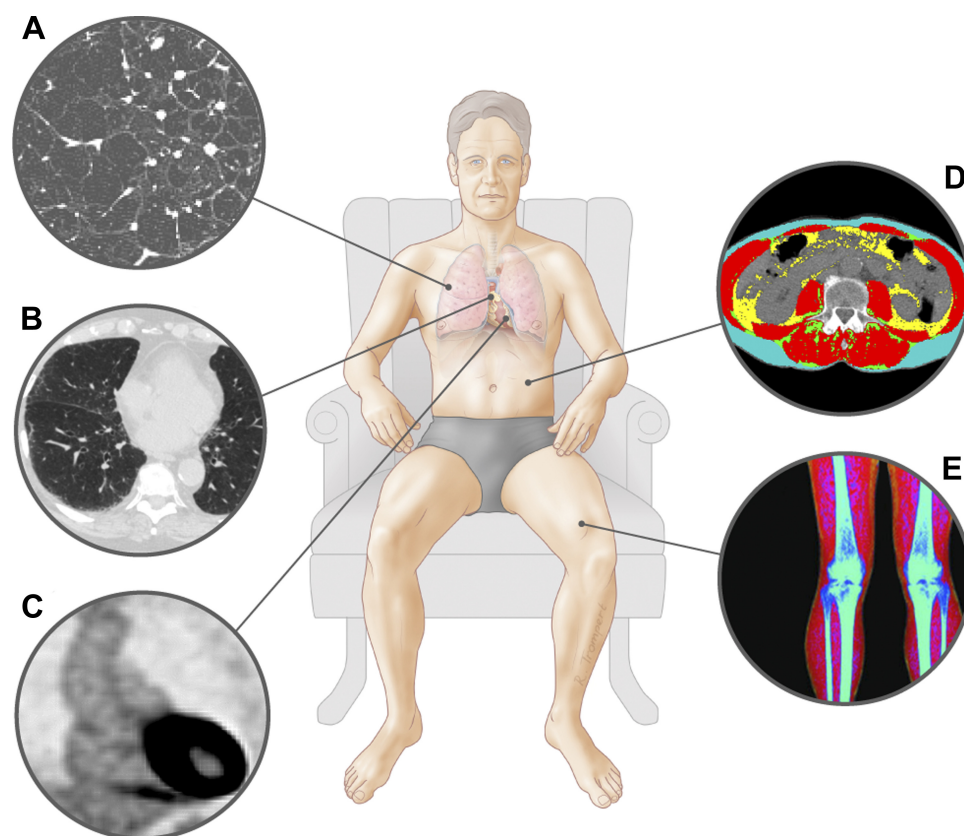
Imaging techniques. *A*: thoracic CT image of patient with emphysema. *B*: thoracic computed tomography (CT) image of patient with interstitial lung abnormalities. *C*: positron emission tomography image displaying fluorodeoxyglucose uptake in the aortic wall (image courtesy of Dr. Jan Bucearius). *D*: abdominal CT with different body composition compartments at the 3rd lumbar vertebra. *E*: dual-energy X-ray absorptiometry scan leg with different body composition compartments.
